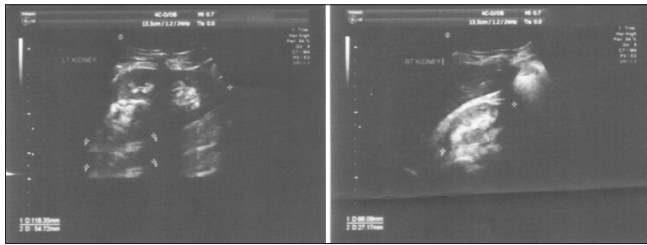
Ultrasonography showing hypoplastic kidney
